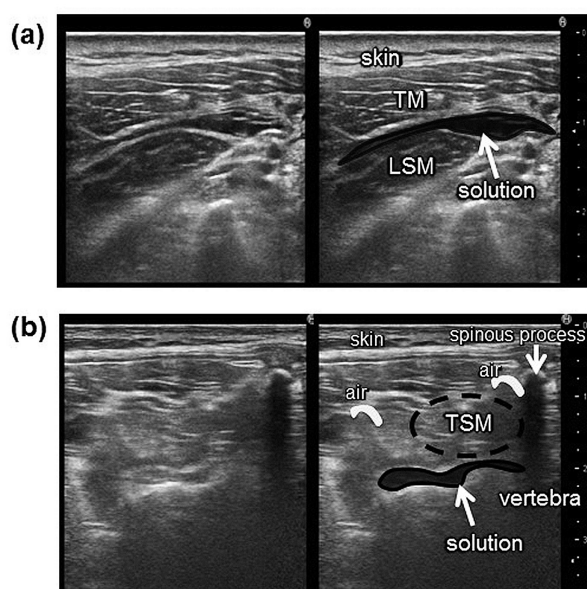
Injected solutions between interfascial spaces under ultrasonography.
